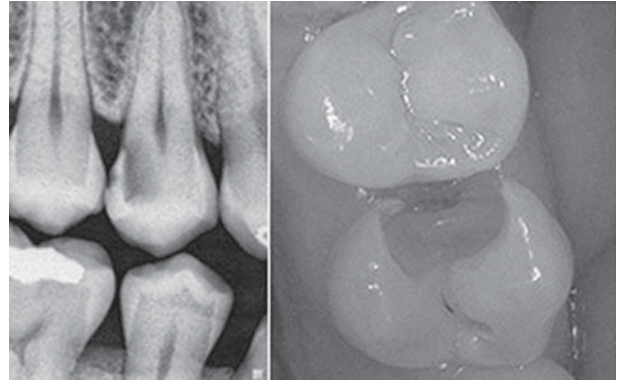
One bitewing radiograph and one clinical picture of the same primary deep carious lesion case in a mature permanent upper right first premolar used to explain the case for participants related to questionnaire. Photos reprinted with permission of Dentaltown.com.
